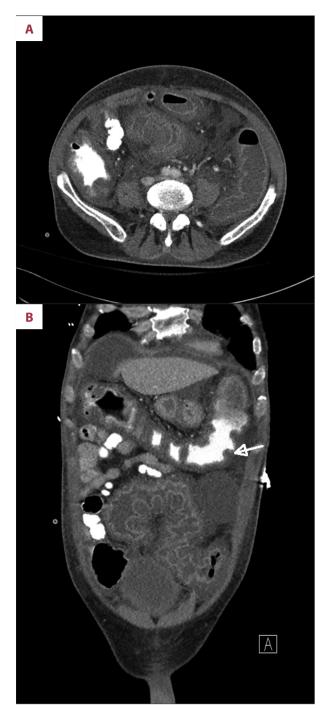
Axial (A) CT and coronal reformat images (B) show diffuse thickening of the colonic wall with some segments having a thumbprinted appearance (arrow).
